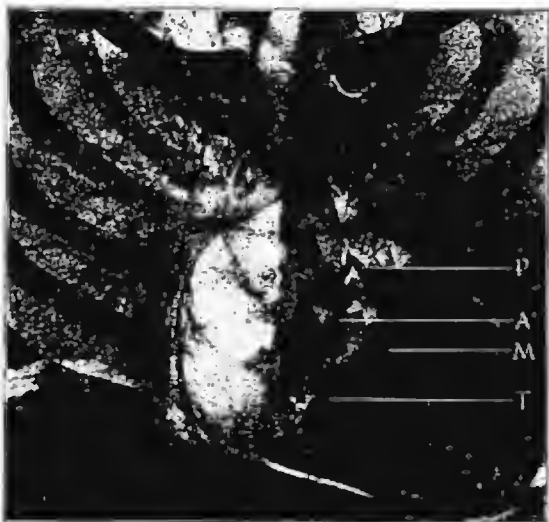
X-ray picture of the thorax, a frontal section of which is shown in Fig. 6. The individual leaflets of the pulmonary and aortic valves are shown with unusual distinctness. All the valves lie approximately one rib below what is described as their normal position. P, pulmonary valve; A, aortic valve; M, mitral valve; T, tricuspid valve.
